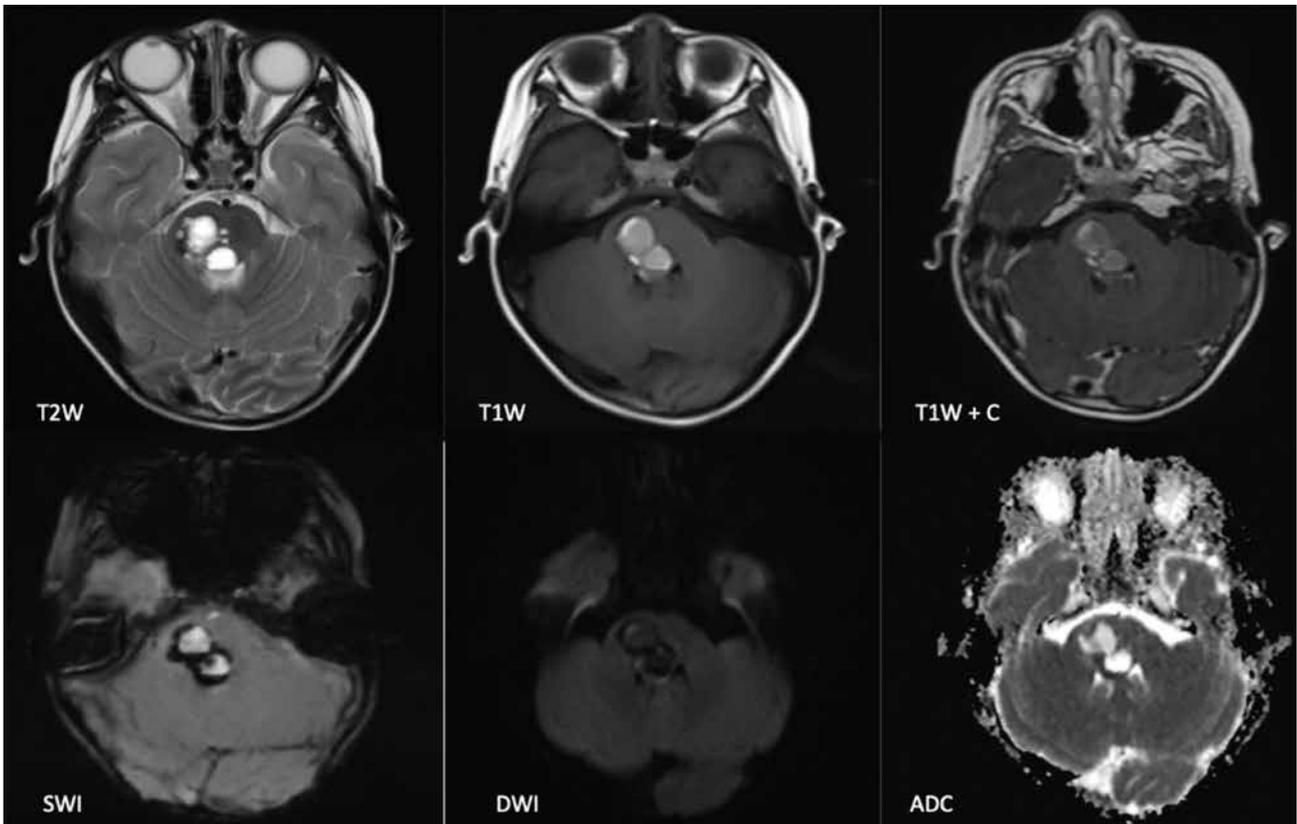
Magnetic resonance imaging brain with sequences as labelled. The pontine lesion showing hyperintense contents on T1- and T2-weighted sequences with a rim of blooming artefact. No significant solid enhancing component or restricted diffusion.
